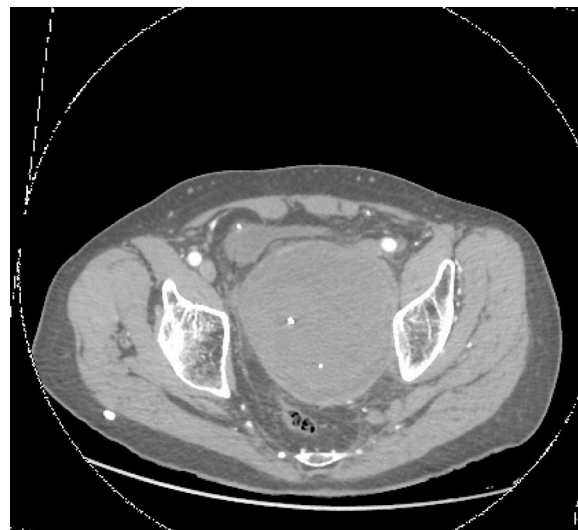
CT: aneurysm of the hypogastric artery compressing the rectum (axial view).
